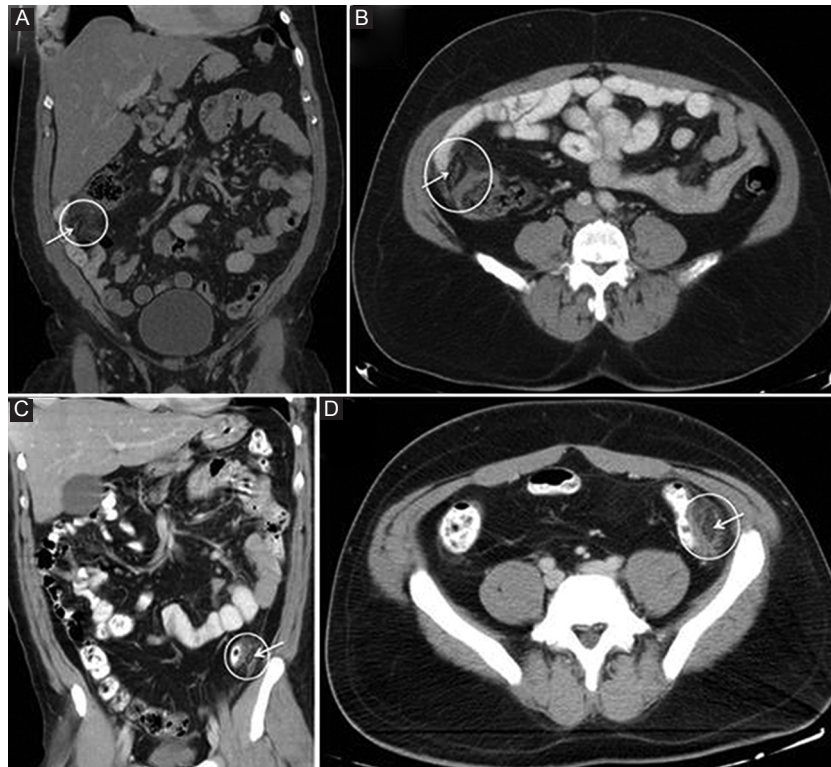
Contrast-enhanced abdominal computed tomography (CT) scans of the patient with right lower quadrant abdominal pain (A: coronal reformat, B: axial) and the patient with left lower quadrant abdominal pain (C: coronal reformat, D: axial). CT demonstrated the presence of oval-shaped, fat density paracolic lesions (white circles) with a high-attenuation central “dot” (white arrow), located at the antimesenteric edge of the ascending colon for the first patient (A, B) and the descending colon for the second patient (C, D), respectively. Inflammatory changes of the adjacent pericolic fat were also detected, more prominent in the second patient
